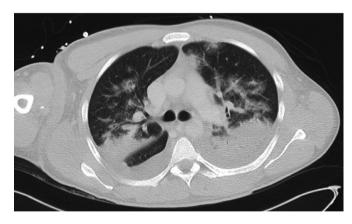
CT Image at day 3 after admission showing lung oedema, pleural effusions, compression atelectasis of both lower lung lobes, and dorsal superior lobes. Ventilated areas showing focal and lobular oedema, and thickening of the interlobular septa.
